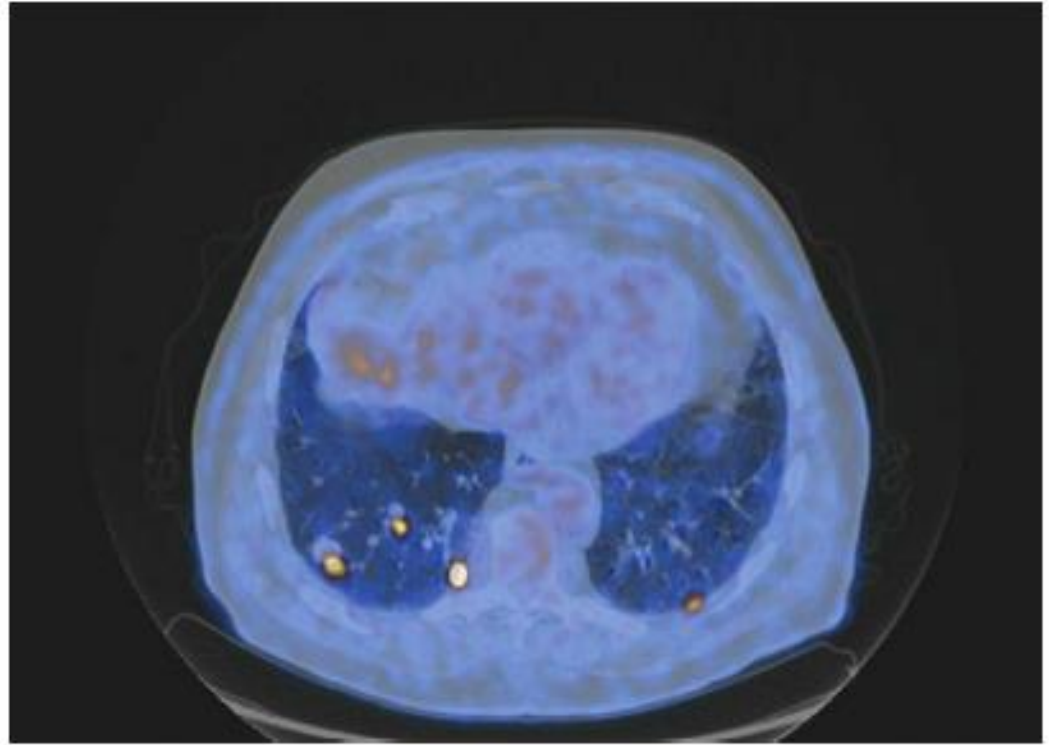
PET/CT maximum intensity projection (MIP) performed under TSH suppression — multiple pulmonary metastasis
